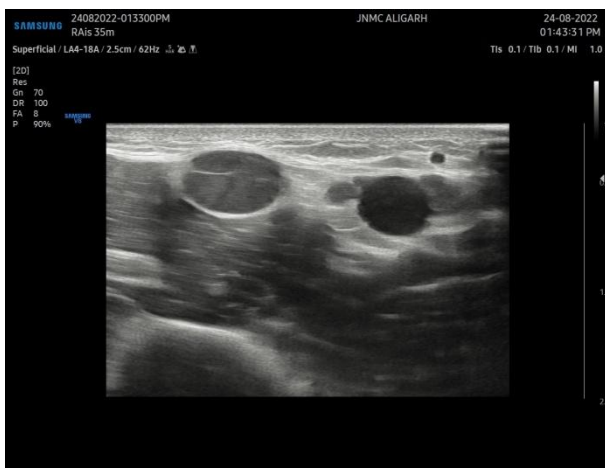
High resolution ultrasound image (transverse view) of ulnar nerve of a leprosy patient showing markedly thickened , hypoechoic nerve with complete loss of fascicular pattern and edema (endoneurial abscess)
